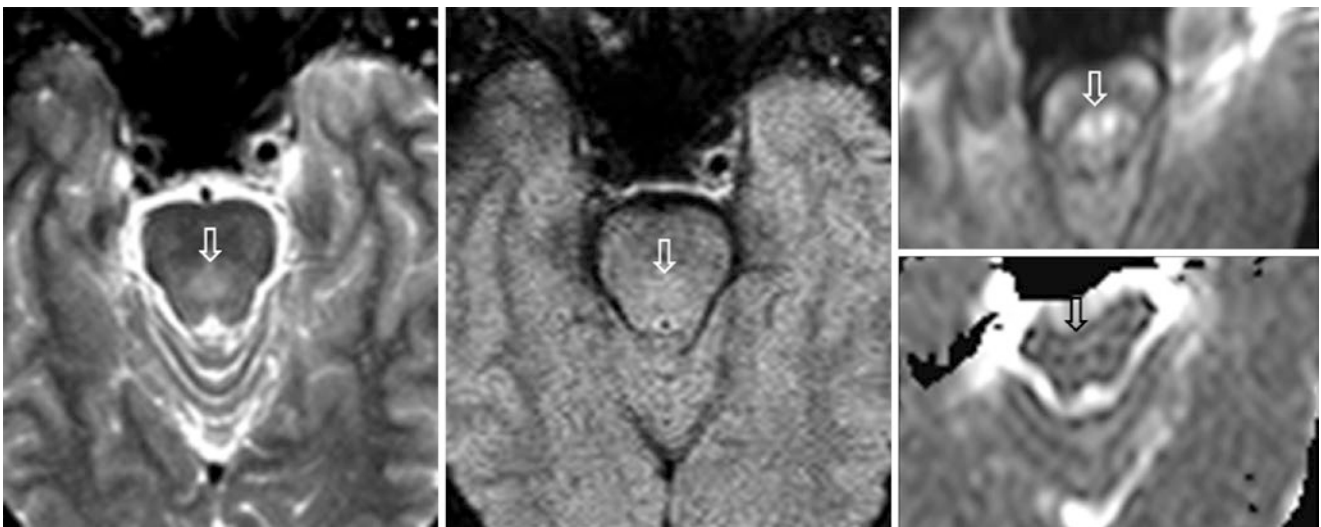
In a 54-year-old with a 1.5 T MRI, the DSCP (*open arrows*) was hyperintense on axial T2WI (*left*) but had near normal signal intensity on FLAIR (*middle*). On DWI, however, the DSCP also appeared quite hyperintense (*right, top image*), with normal signal intensity on
